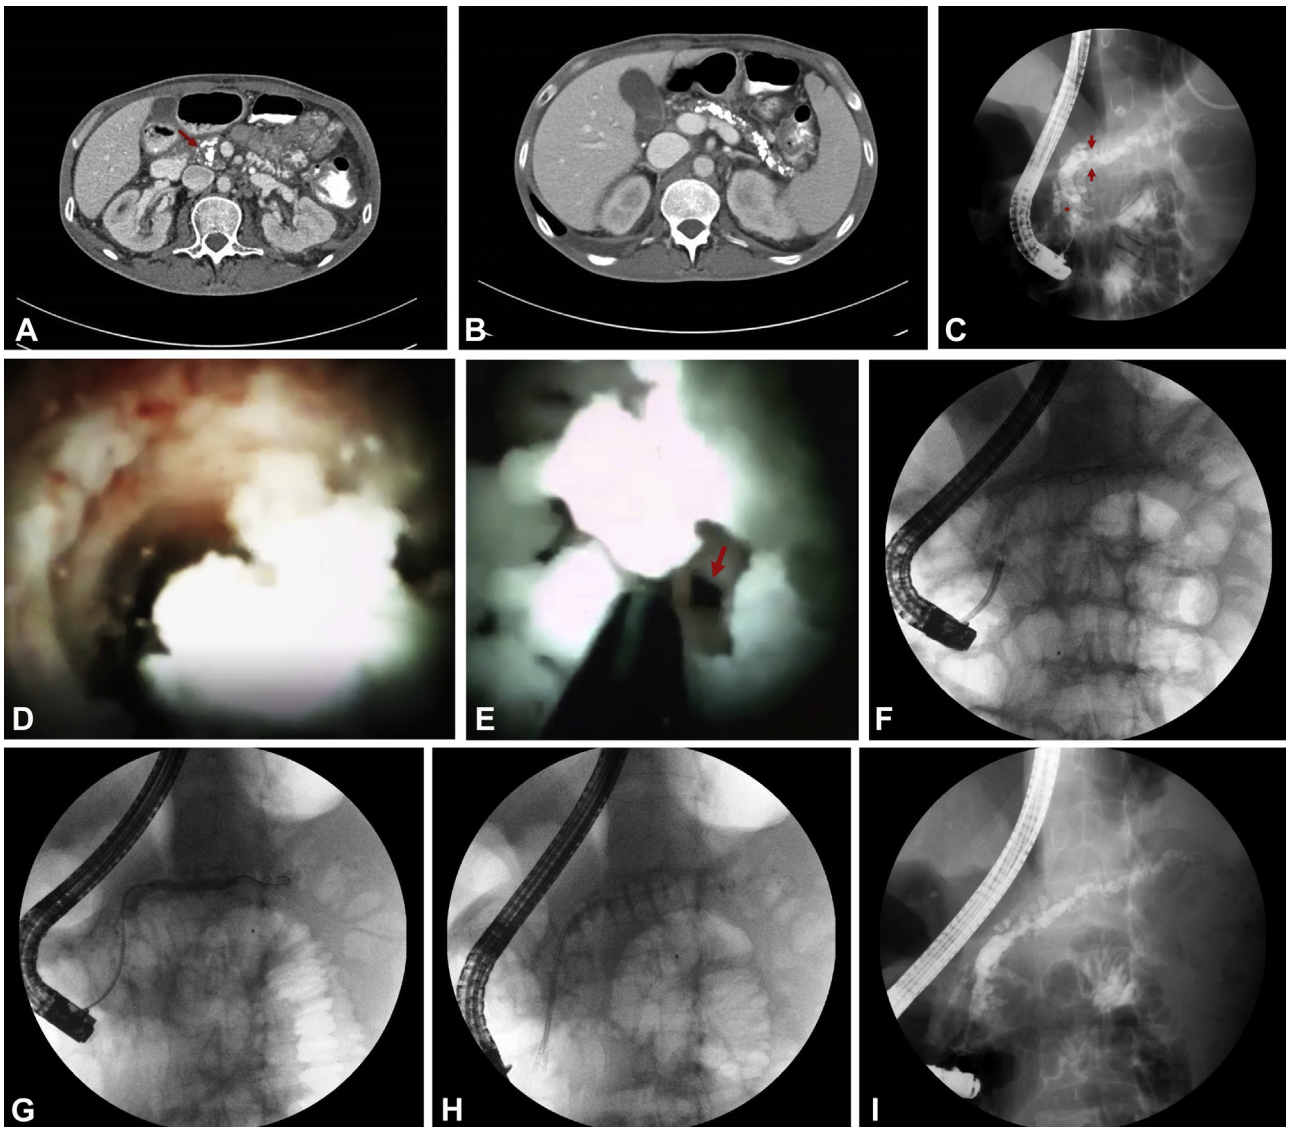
A, B, Contrast-enhanced CT images in a patient with chronic calcific pancreatitis. A, Enlarged pancreatic head with multiple parenchymal and intraductal calcifications (*arrow*). B, Atrophic and heterogeneous pancreas with multiple parenchymal calcifications and ductal stones. C, Initial pancreatogram showing markedly dilated pancreatic duct, multiple filling defects, an obstruction in the head (*asterisk*), and a pronounced obstruction in the distal body (*arrows*). D, Pancreatoscopic digital image of the distal pancreatic body showing obstruction of lumen caused by large intraductal stones. E, Pancreatoscopic digital image of the distal body stricture (*arrow*), which was revealed after pancreatoscopy-guided intraductal lithotripsy. F, Fluoroscopic images showing outcomes after electrohydraulic lithotripsy of the ductal stones. Digital pancreatoscope direction of cannulation of the distal body obstruction by the guidewire. G, Balloon dilatation, up to 6 mm, of the stricture associated with the distal body obstruction. H, Stent placement in the head and pancreatic body with 2 stents, 7F × 9 cm and 7F × 12 cm. I, Pancreatogram after cessation of endotherapy and electrohydraulic lithotripsy, revealing stone clearance and improvement of obstruction.
